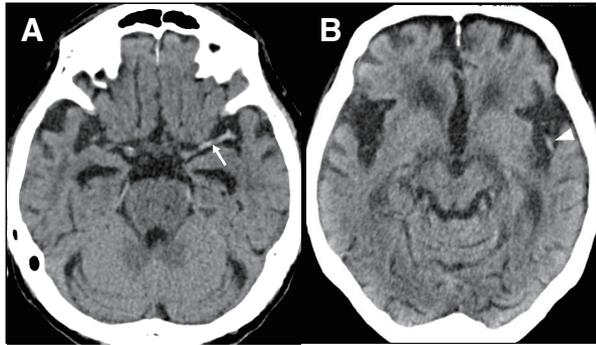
Hyperdense artery signs on non-contrast CT in the M1 segment of the left MCA (arrow, A) and M2 segment of the left MCA (arrow head, B). MCA: middle cerebral artery
